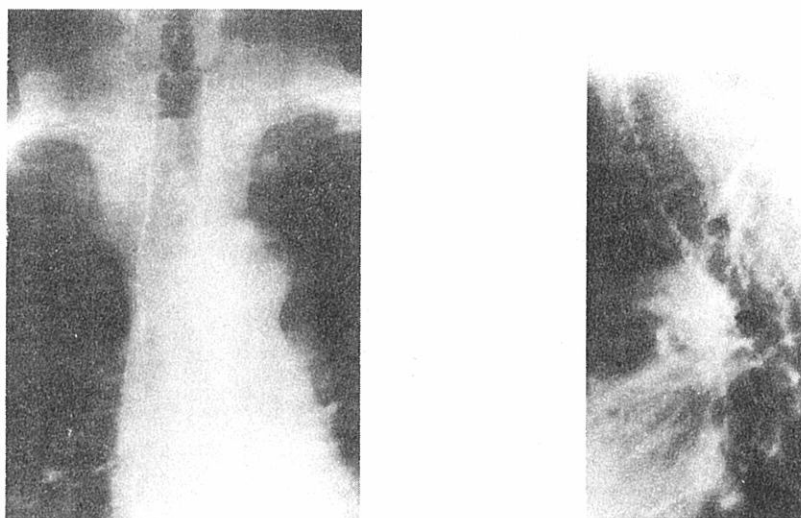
Posteroanterior (A) and lateral (B) chest radiographs of the same case as Figure 1, 12 years later, showing that the calcification has become very extensive.
